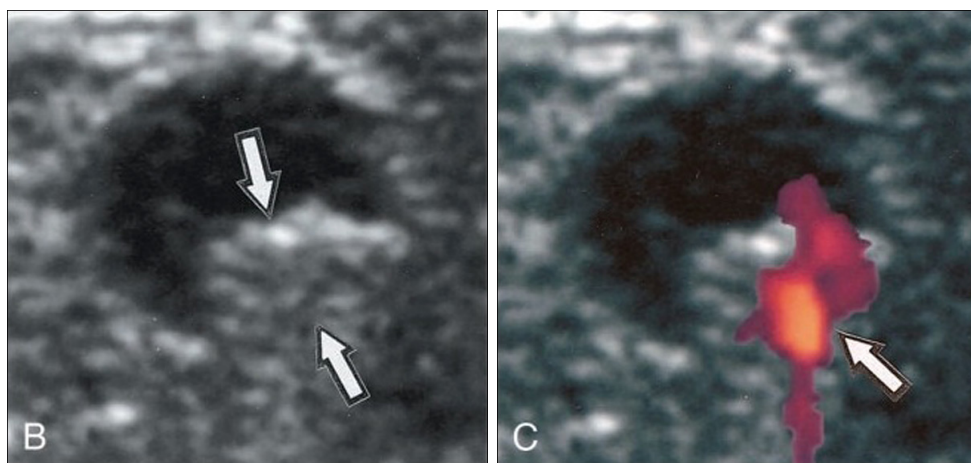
Doppler ultrasonography for regional lymph node metastasis
